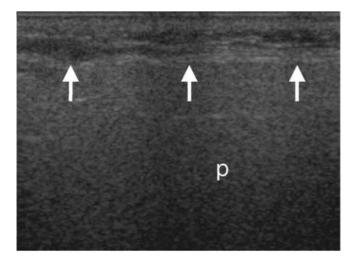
Ultrasound image of the normal homogenous echotexture of a parotid gland (P) with distinct borders (arrows). From Figure 1A of Hocevar A, Ambrozic A, Rozman B, Kveder T, Tomsic M. Ultrasonographic changes of major salivary glands in primary Sjogren's syndrome: diagnostic value of a novel scoring system. *Rheumatology*, 2005;44:768–772.
